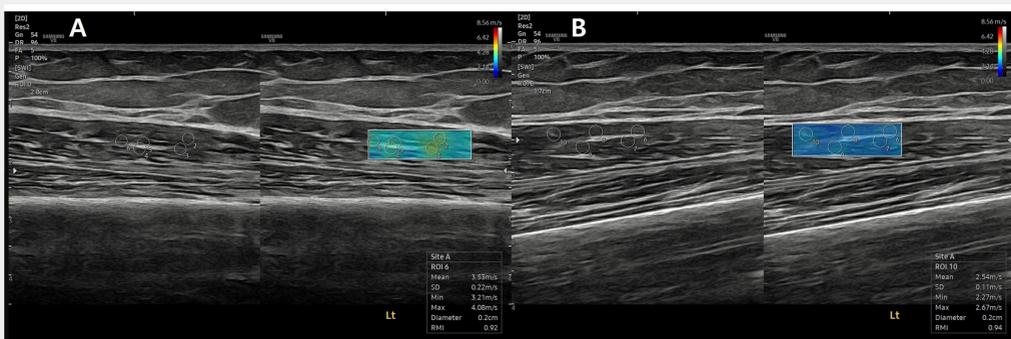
Shear wave ultrasound elastography images of the right quadriceps muscle before(A) and after(B) rESWT application. The shear wave speed improved from 3.53 m/s to 2.54 m/s after five sessions of rESWT.
